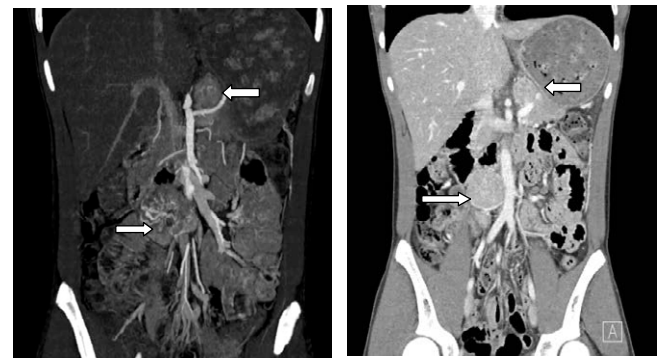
Coronal abdominal MRI showing well circumscribed upper and lower masses along each side of the aorta measuring 25x26x30 mm and 45x35x50 mm, respectively (arrows). The lower mass shows inner central hemorrhage and necrosis. The two masses show obvious intensification after injection of contrast medium.
